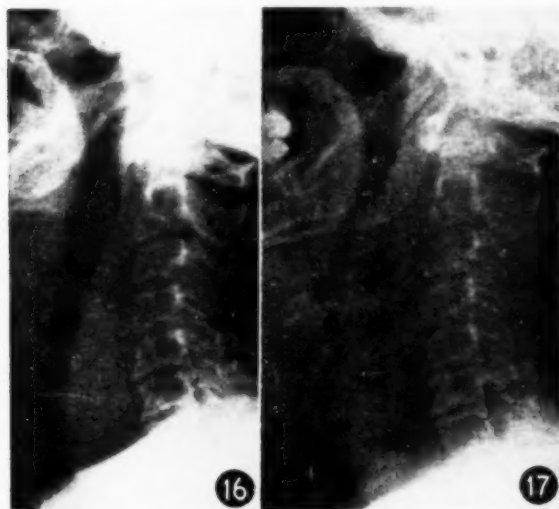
(Case 15). Lateral X-ray of the neck showing a retro-tracheal oesophageal swelling 2 days after a diagnostic oesophagoscopy.
